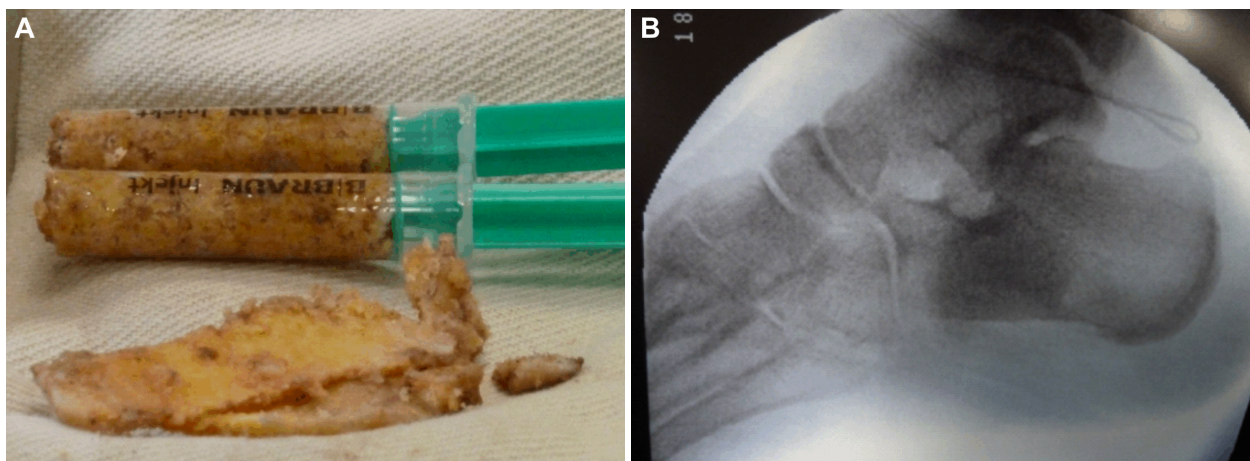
Morselized bone allograft prepared for injection in the cyst cavity (A) and intraoperative radiographic confirmation of adequate bone grafting (B).
